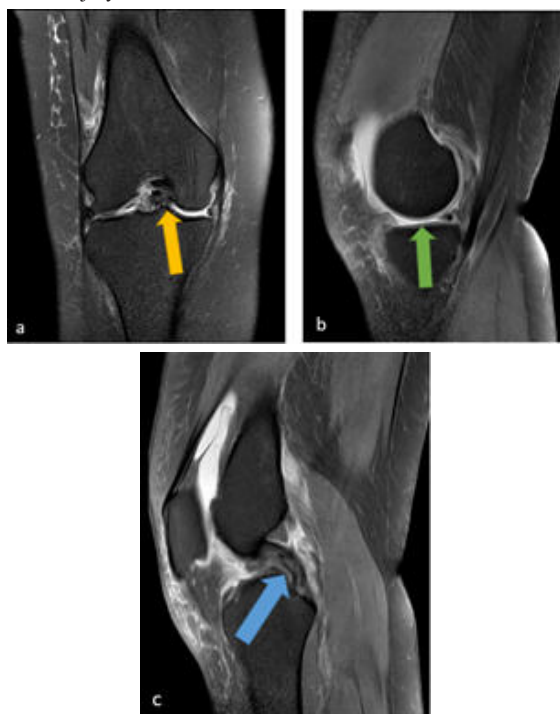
(a) PDFS coronal MR image showing meniscal fragment in intercondylar notch (yellow arrow). (b) PDFS sagittal image showing absent bow-tie sign (green arrow) and (c) sagittal image showing double PCL sign (blue arrow) findings are suggestive of Bucket Handle tear of medial meniscus.
